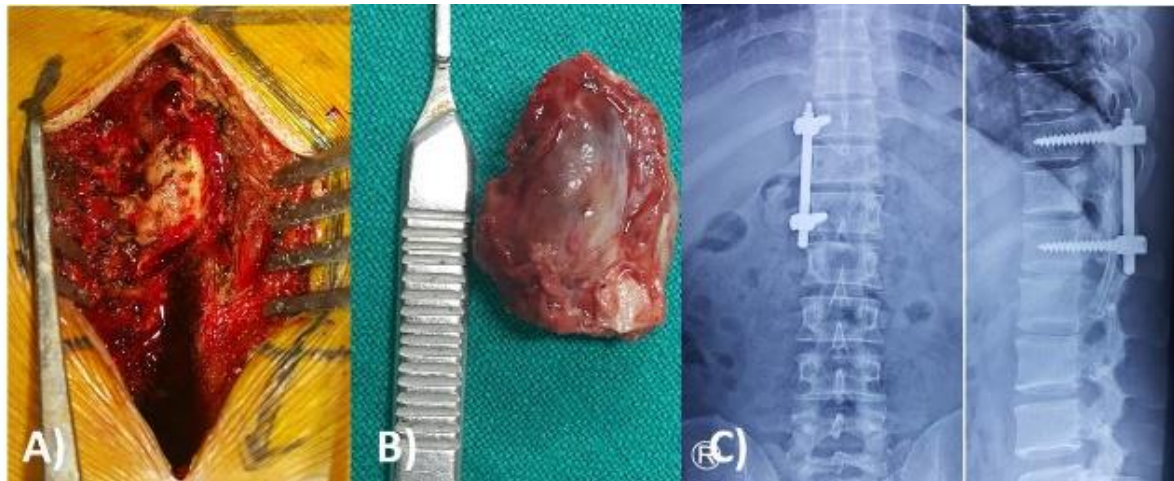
A, B) Lesion before and after excision, C) Post op X-rays after excision
